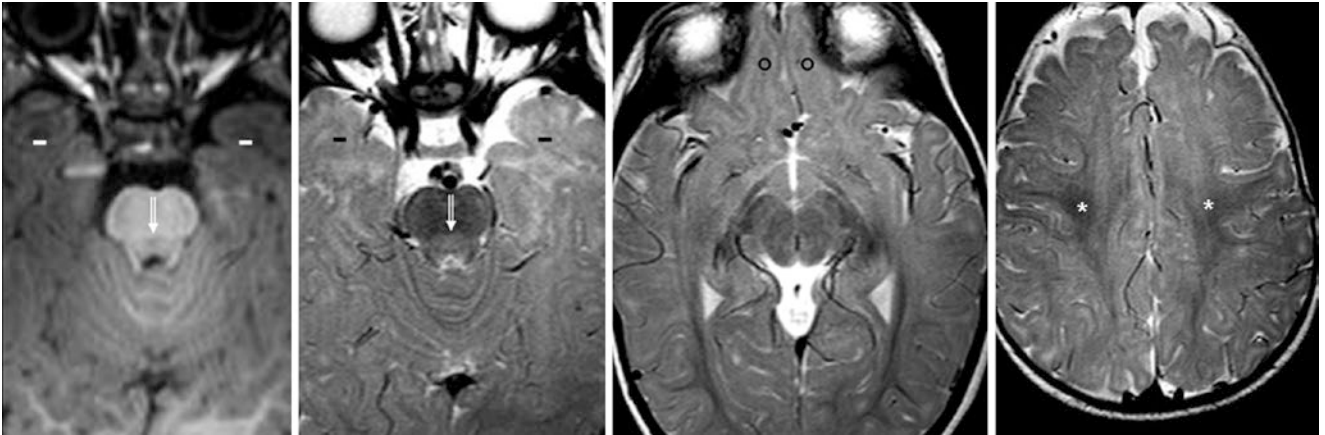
A 10-month-old with a seizure had a negative 3T MRI, and developed normally. A GE T1WI (*left*) shows the dorsal pons (*beveled arrows*) to be slightly dark, but better visualized as bright on SE
